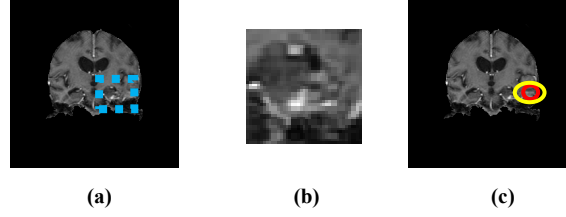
The misclassified MRI scan 536_47 of IBSR (536_T1) dataset, (a) Original MRI slice 31 with tumour inside marked blue Square, (b) Zoomed in marked area, and (c) Misclassified blocks, where the red circle indicates wrongly classified blocks and yellow circle represents the tumour area
